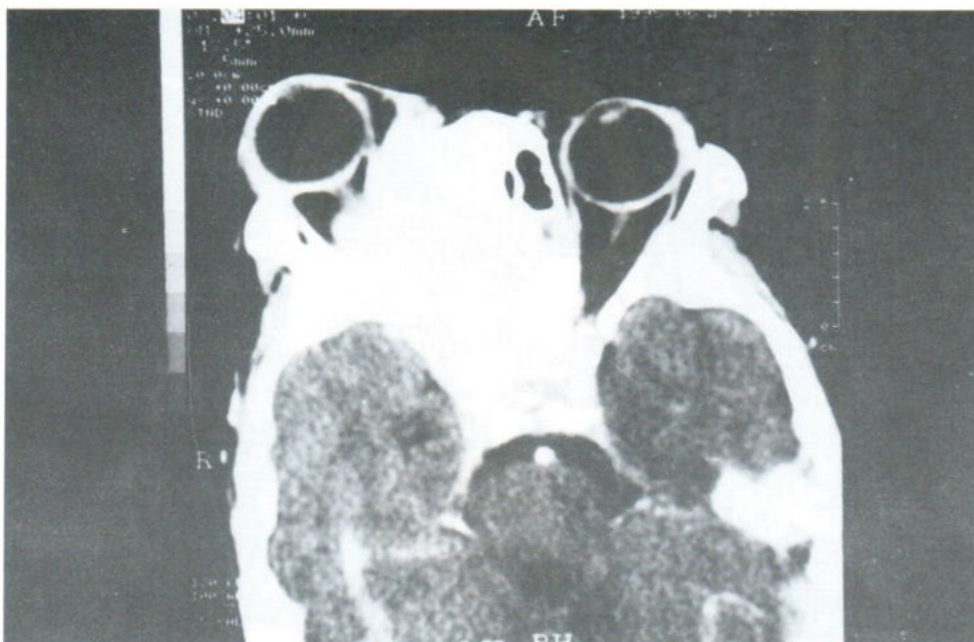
Acute Myeloblastic Leukemia: CT scan of 8-year-old girl shows large, enhanced, infiltrative mass involving paranasal sinuses with bone destruction and extension into both extra- and intraconal spaces of right orbit.
